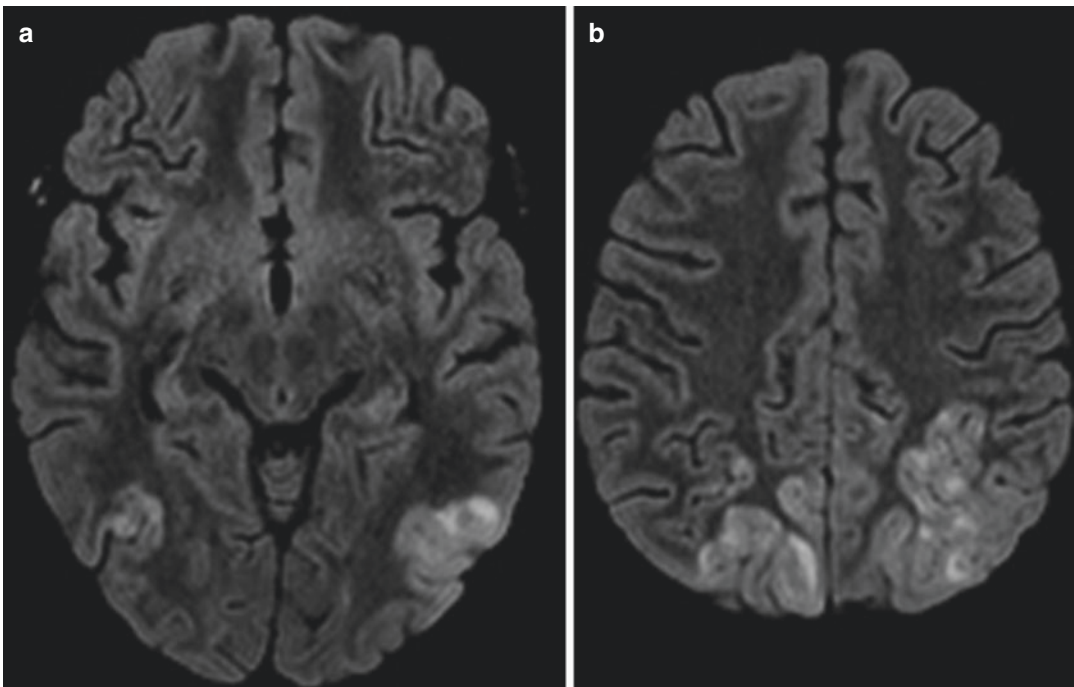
PRES. Axial FLAIR-weighted images at the planes of temporal lobes (a) and parietal convexities (b) show bilateral vasogenic edema involving cortical/subcortical regions at posterior watershed zones
